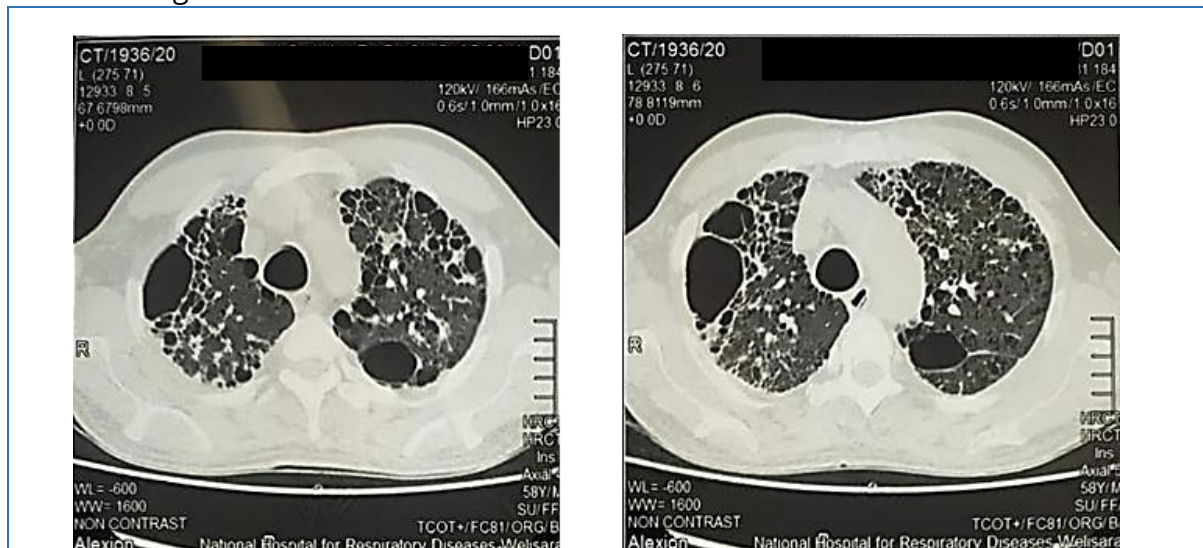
High resolution computed tomography of the thorax lung window axial section showing nodules and bizarre shaped thick walled cysts.
